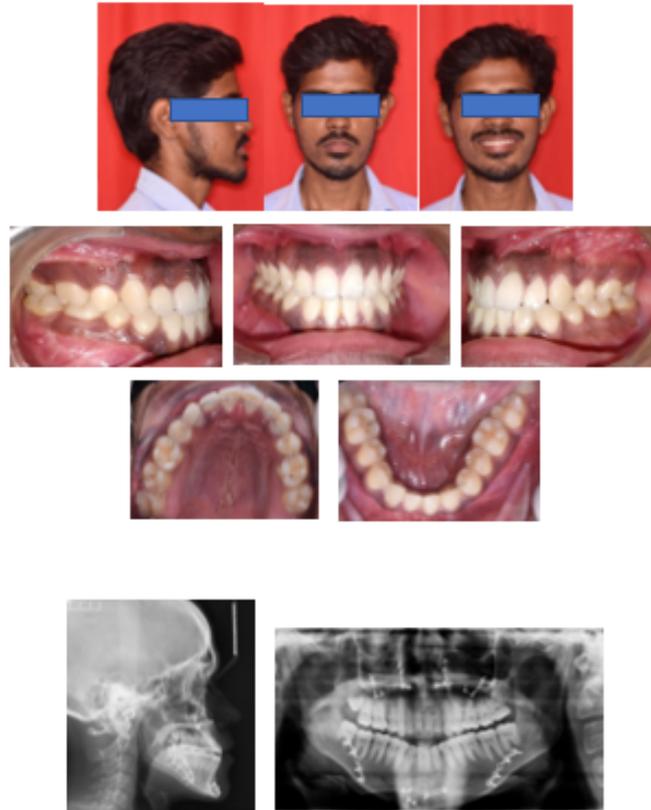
Follow-up photographs and radiographs
